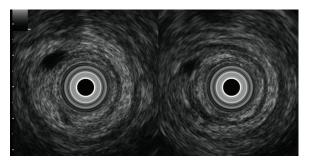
Endoanal ultrasound of anal duct cyst.
